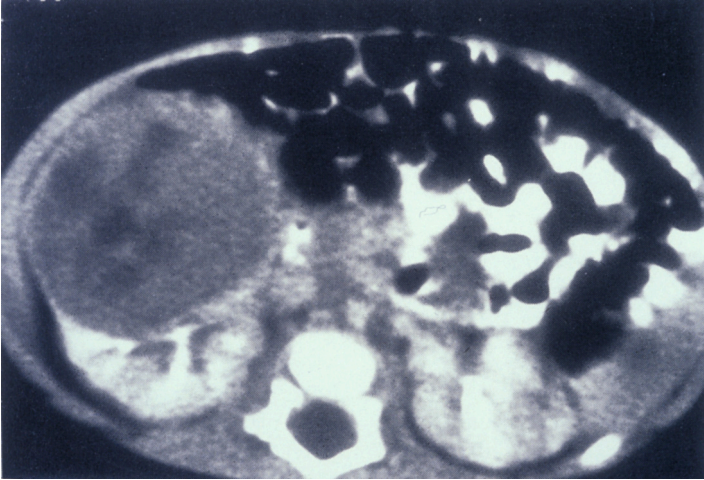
Computed tomography image of a neuroblastoma.
